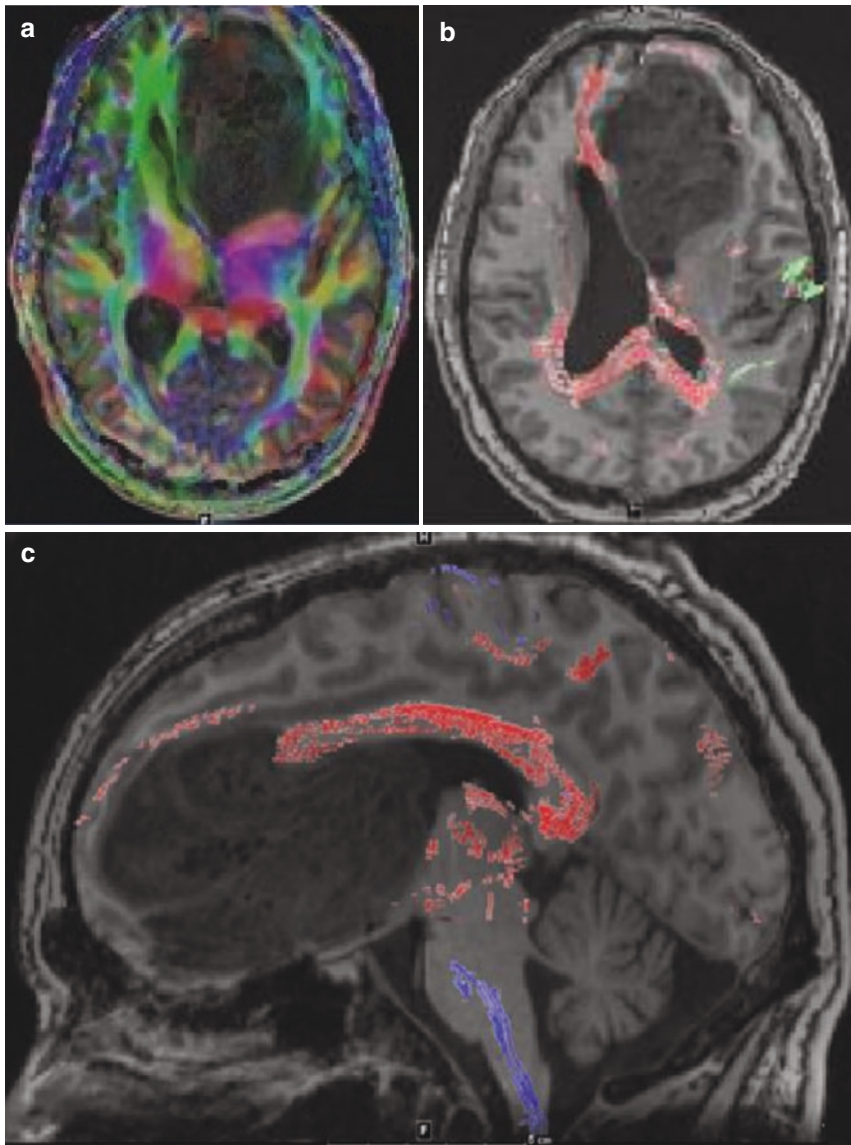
Selected MR images of a 26-year-old patient with a large glioblastoma in the anterior left frontal lobe. (a) Axial DTI. (b) Axial tractography. (c) Sagittal tractography
